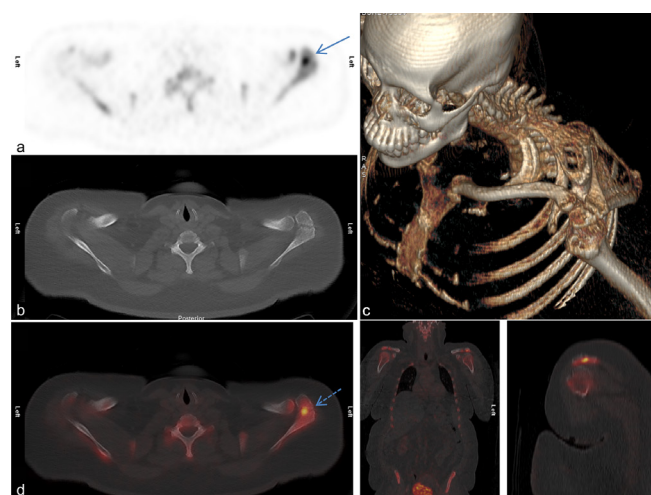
A 52-year-old female with left breast cancer, complaining of left shoulder pain. (a) Axial NaF shows increase tracer activity in the left acromial region (arrow). (b and c) CT and volume rendering CT images show unfused left anterior acromial ossification centre with an irregular border. (d) NaF Fused axial, coronal and sagittal images show focal increase tracer uptake at this articulation site (dotted arrow). Findings are consistent with osteoblastic activity in the left OA, which was congruent with symptoms on clinical review. NaF, Sodium Fluoride; OA, os acromiale.
